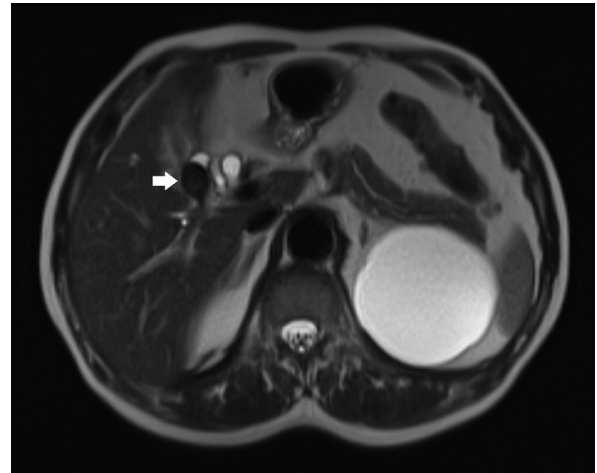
Preoperative axial T2 magnetic resonance imaging demonstrates an area of flow void arising from the right hepatic artery consistent with a hepatic pseudoaneurysm (arrow)
